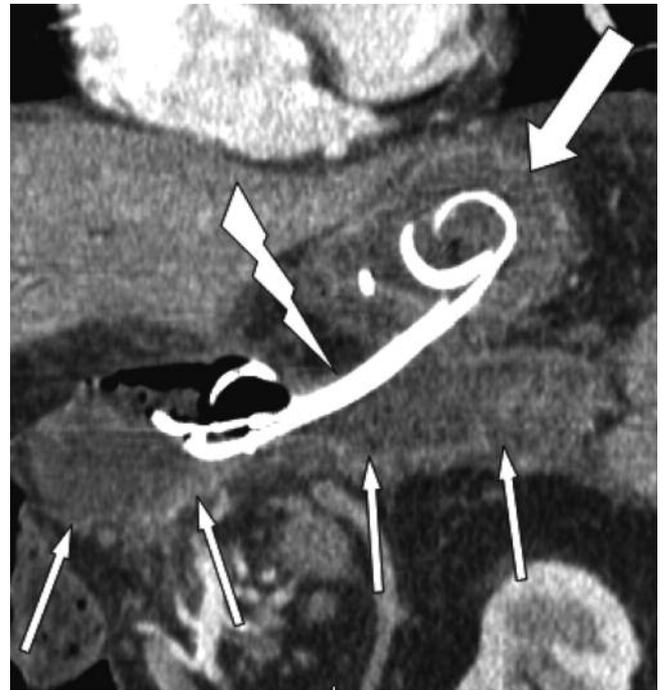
CT control of the drainage: oblique coronal reconstruction showing the double drain (lightning) between the remaining stomach (Billroth II, thick arrow) and the pancreatic collection (thin arrows) which begins to decrease in size.
